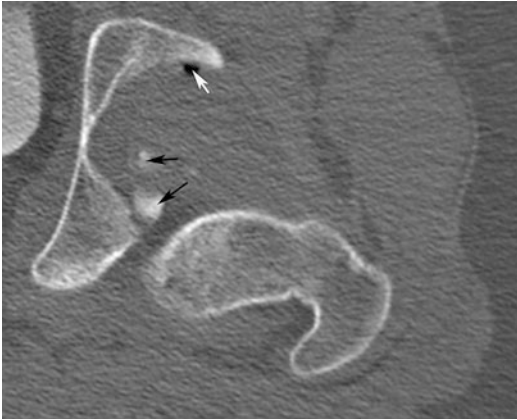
Axial CT image through the left hip from a CT of the abdomen and pelvis in an 18-year-old female s/p high speed MVA demonstrates posterior dislocation of the femur with at least two posterior acetabular wall fracture fragments projecting in the joint space (*black arrows*) and a small focus of gas within the joint (*white arrow*). This patient required surgical reduction of the hip with open reduction and fixation of the posterior wall fracture fragments
